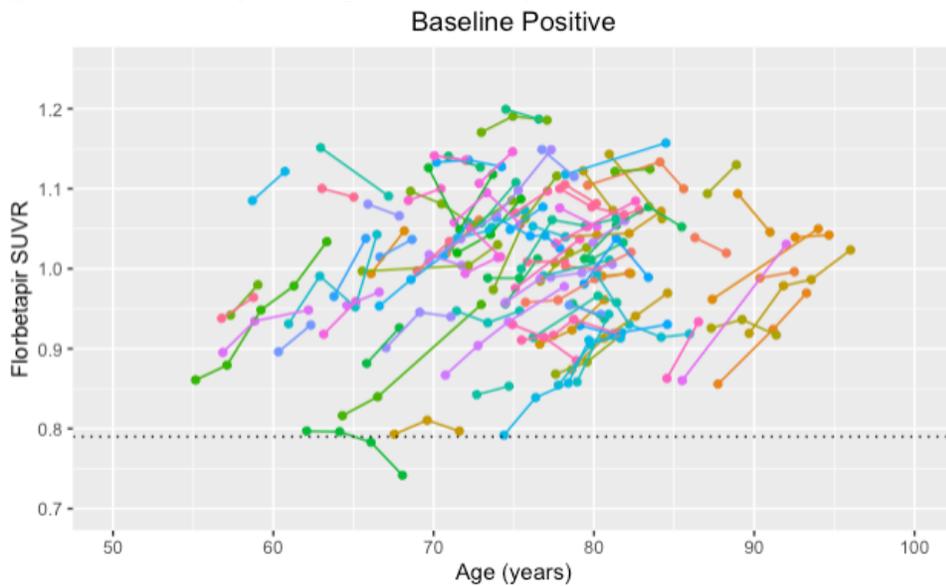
1B, 1C, and 1D depict the florbetapir standardized uptake value ratio (florbetapir SUVR) as a function of time for each individual subject with at least two PET scans. Individuals were separated between those who were baseline positive (Figures 1B and 1D) and those who were baseline negative for amyloid accumulation (Figures 1A and 1C). Of the participants who were cognitively normal at the start of the study, represented by Figures 1A and 1B, most of the participants in Figure 1B, who were baseline positive, remained florbetapir-positive throughout the study. Likewise, many of the participants in Figure 1A, who were baseline negative, remained florbetapir-negative throughout the study. However, many of the participants in Figure 1A also became florbetapir-positive at some point during the study. These individuals'
